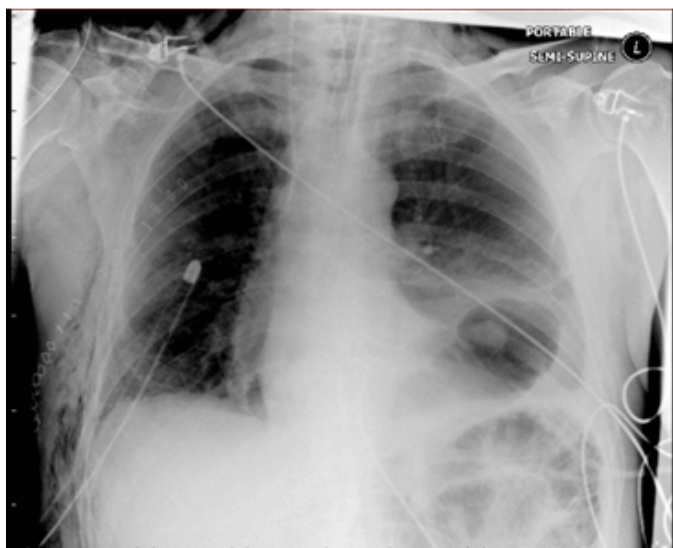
Chest X-ray taken on the third postoperative day. There is an acute diaphragmatic hernia with colon visible in the left hemithorax. Note the apical drain in the right hemithorax. The pneumothorax has increased slightly in size and there is new surgical emphysema of the chest wall.
